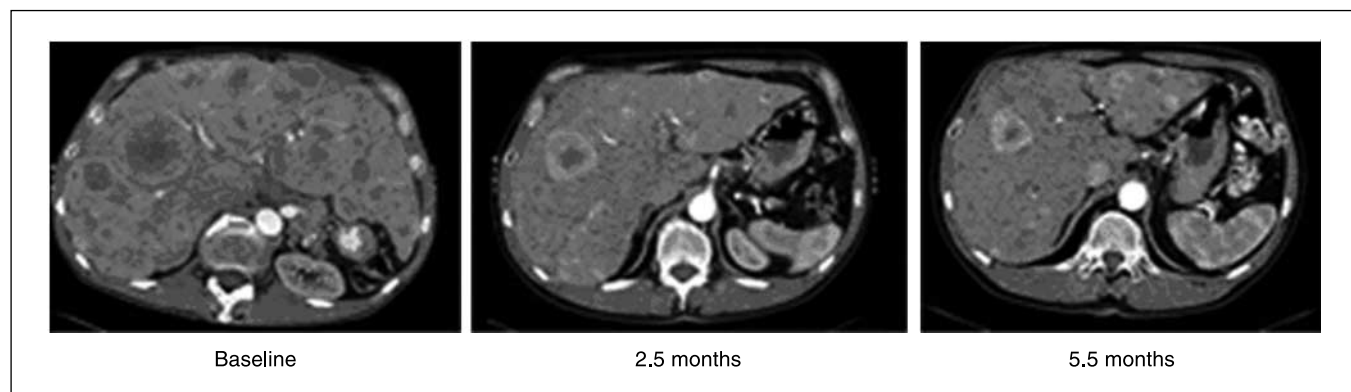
Computed tomography images of a male patient (born 1950) with EPT: 2.5 mo after start of temozolomide treatment, there was a 59% tumor reduction (Response Evaluation Criteria in Solid Tumors criteria), and at 5.5 mo (2.5 mo after the end of follow-up for this study) there was an 89% reduction compared with baseline.
